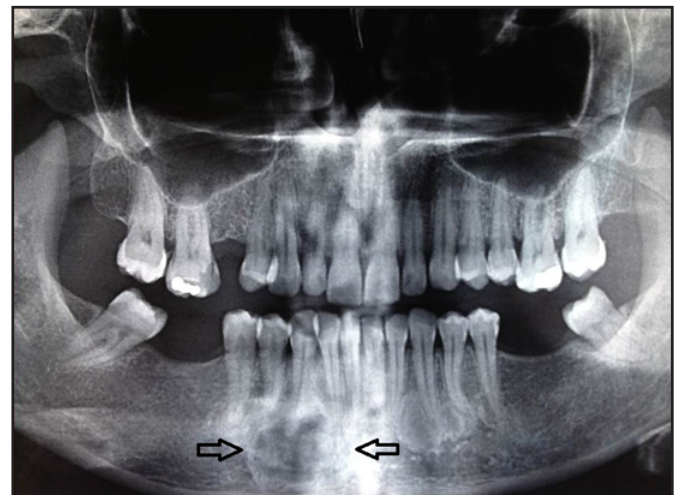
Ground-glass appearance of the lesion on panoramic radiography.
